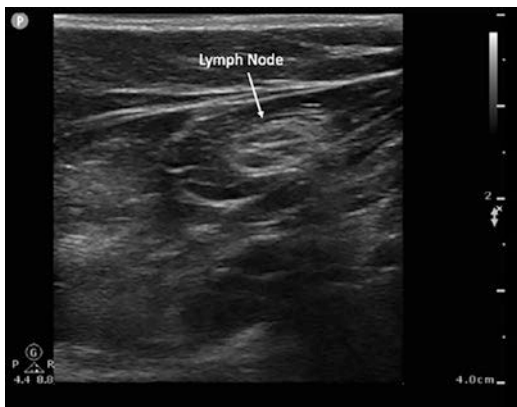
Ultrasound image of a lymph node
